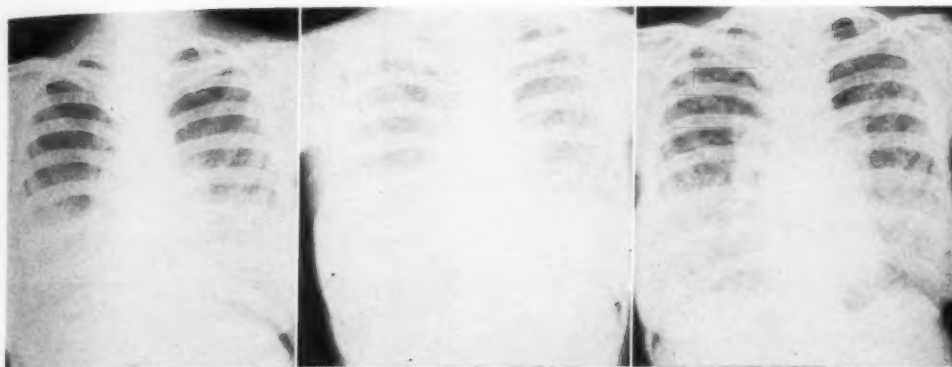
Pulmonary granulomatosis following exposure to fluorescent powders. Onset of symptoms four years after exposure. Fig. 10 (left). Early roentgenogram showing fine granularity with some nodularity. Fig. 11 (center). One year later. Nodularity more distinct. Fig. 12 (right). Eighteen months after onset. Nodularity more pronounced, with increased size of nodules and areas of intervening emphysema. Nodularity at the hila.
